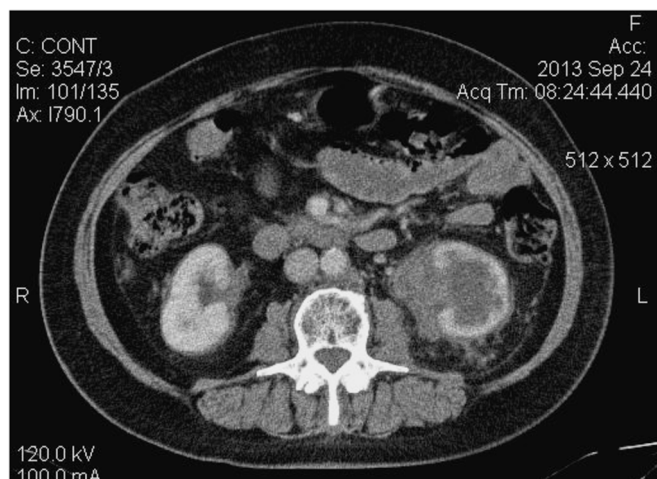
CT that shows the mass of approximately $5 \times 4.1 \times 2.4$ cm in relation to the left renal pelvis associated with moderate-accentuated hydronephrosis.
